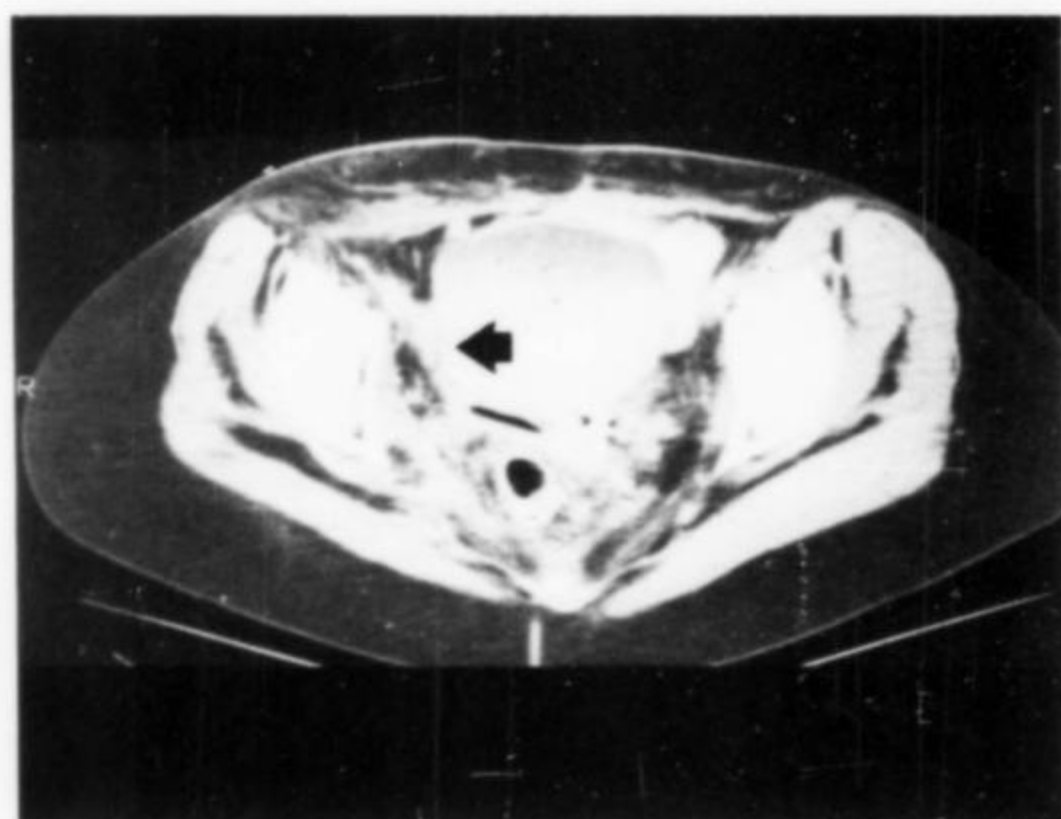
Pelvic CT scan showing only a residual density (arrow) in the area of the tumor after treatment with medroxyprogesterone acetate.
